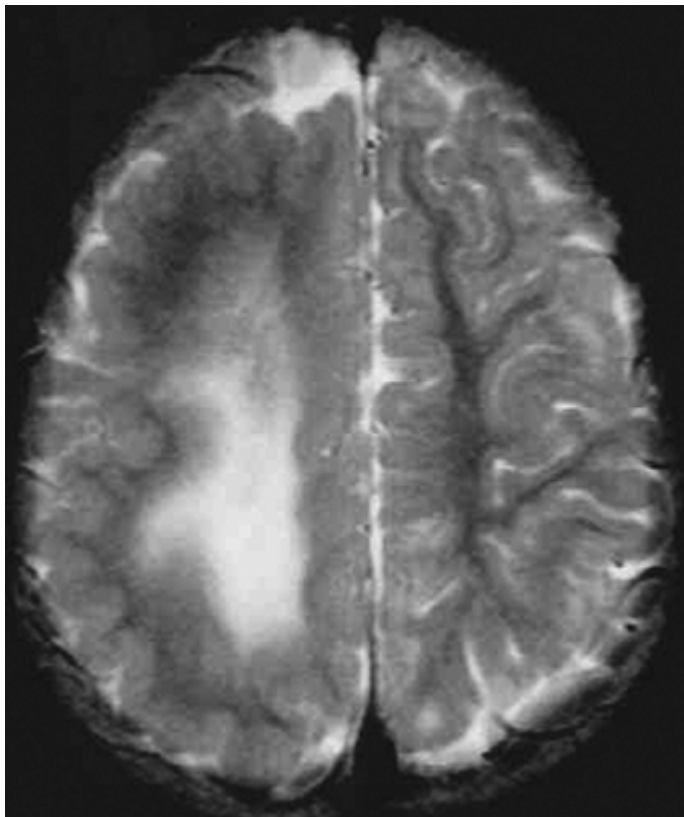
Hemimegalencephaly. Axial T2-weighted magnetic resonance image shows abnormal left hemisphere with smooth cortex and white matter changes.
